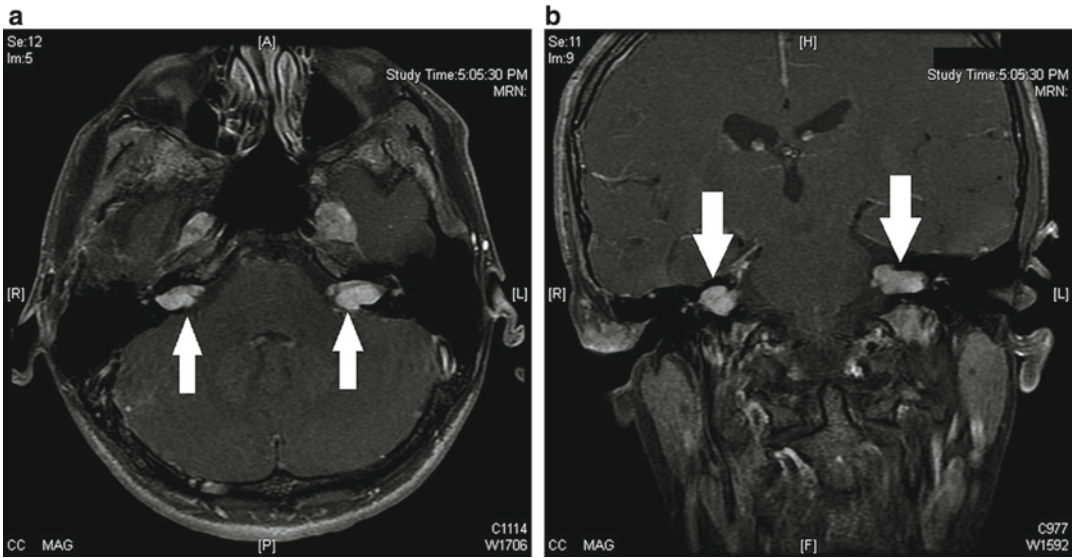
Bilateral vestibular schwannomas in a patient with NF2 shown on MRI in axial (a) and coronal (b) views
